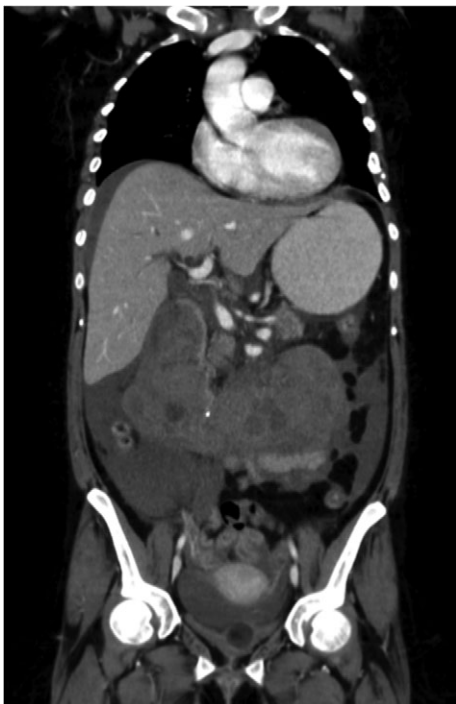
A coronal section of a venous phase abdominal CT demonstrating the end of the IVC filter strut penetrating the wall of the third part of the duodenum.
